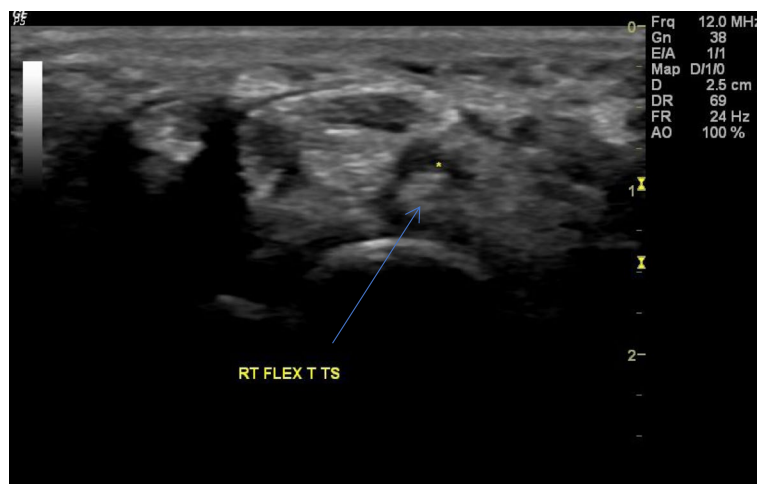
Ultrasound scan showing gray scale ultrasound transverse palmar scan of the median nerve with flexor tendon below the nerve at the carpal tunnel showing the hypoechoic area surrounding the flexor tendon (blue arrow) indicating flexor tendon (FT) tenosynovitis (yellow star)
